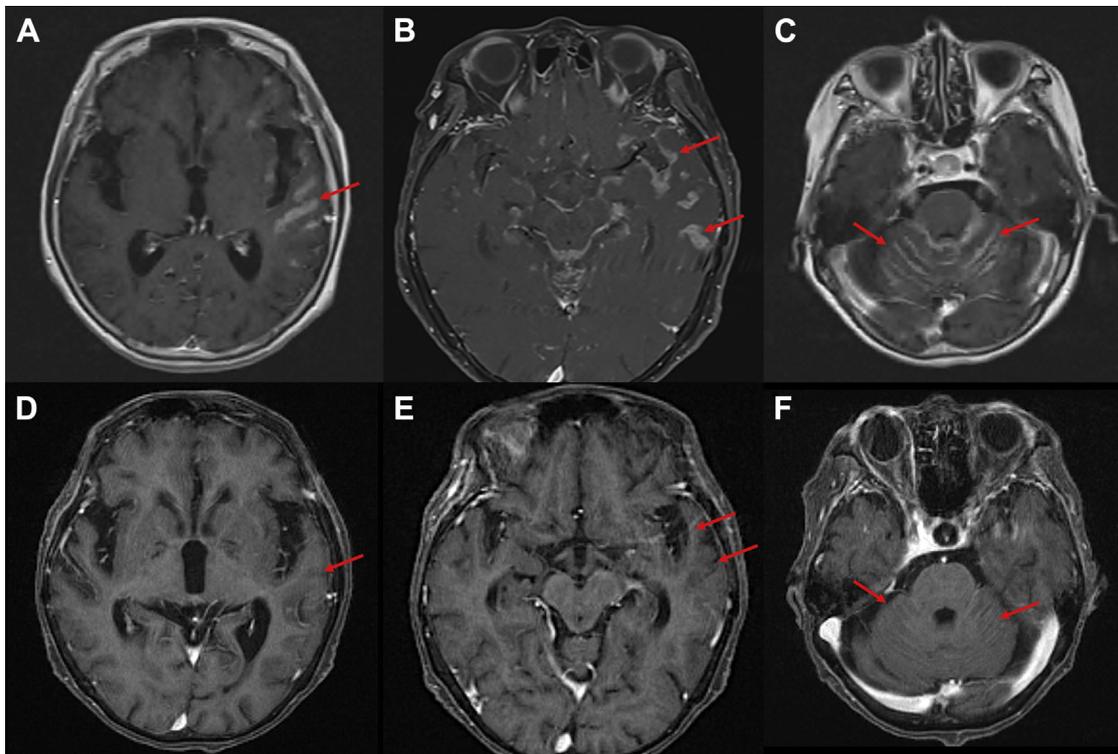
Zuckerguss appearance of leptomeningeal carcinomatosis in *EGFR*-mutant NSCLC. Brain magnetic resonance imaging demonstrated extensive leptomeningeal enhancement on the postcontrast T1-weighted images, especially within the left Sylvian fissure and the bilateral cerebellar hemispheres (A-C [red arrows]). Resolution of Zuckerguss appearance after pulse dose erlotinib weekly (D-F [red arrows]).
